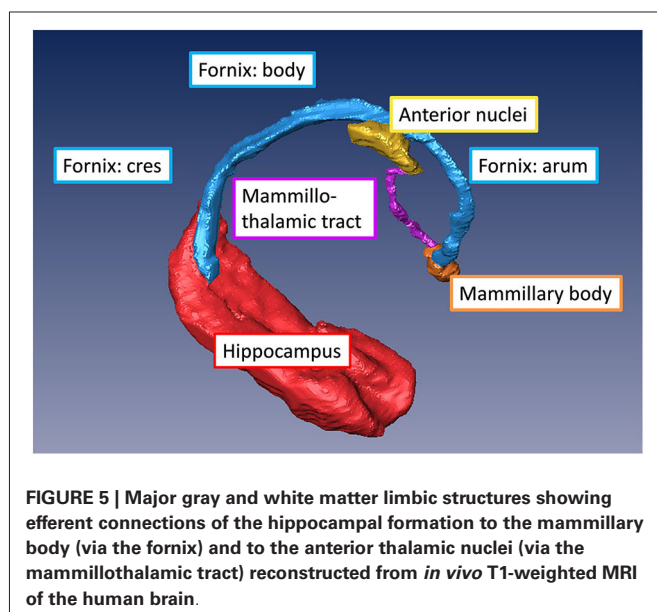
Major gray and white matter limbic structures showing efferent connections of the hippocampal formation to the mammillary body (via the fornix) and to the anterior thalamic nuclei (via the mamillothalamic tract) reconstructed from *in vivo* T1-weighted MRI of the human brain.
